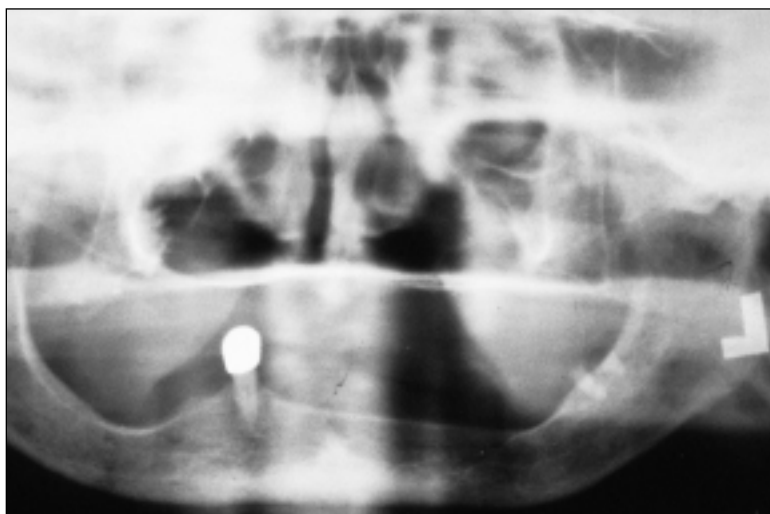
Initial conditions on panoramic radiograph. It proved to be impossible to obtain any microradiograms.
